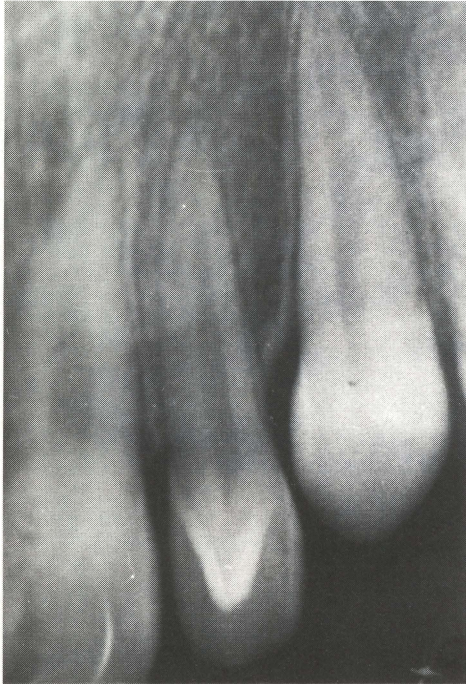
Radiograph of Case 6 indicating pulp extension limited to the base of the cusp.
